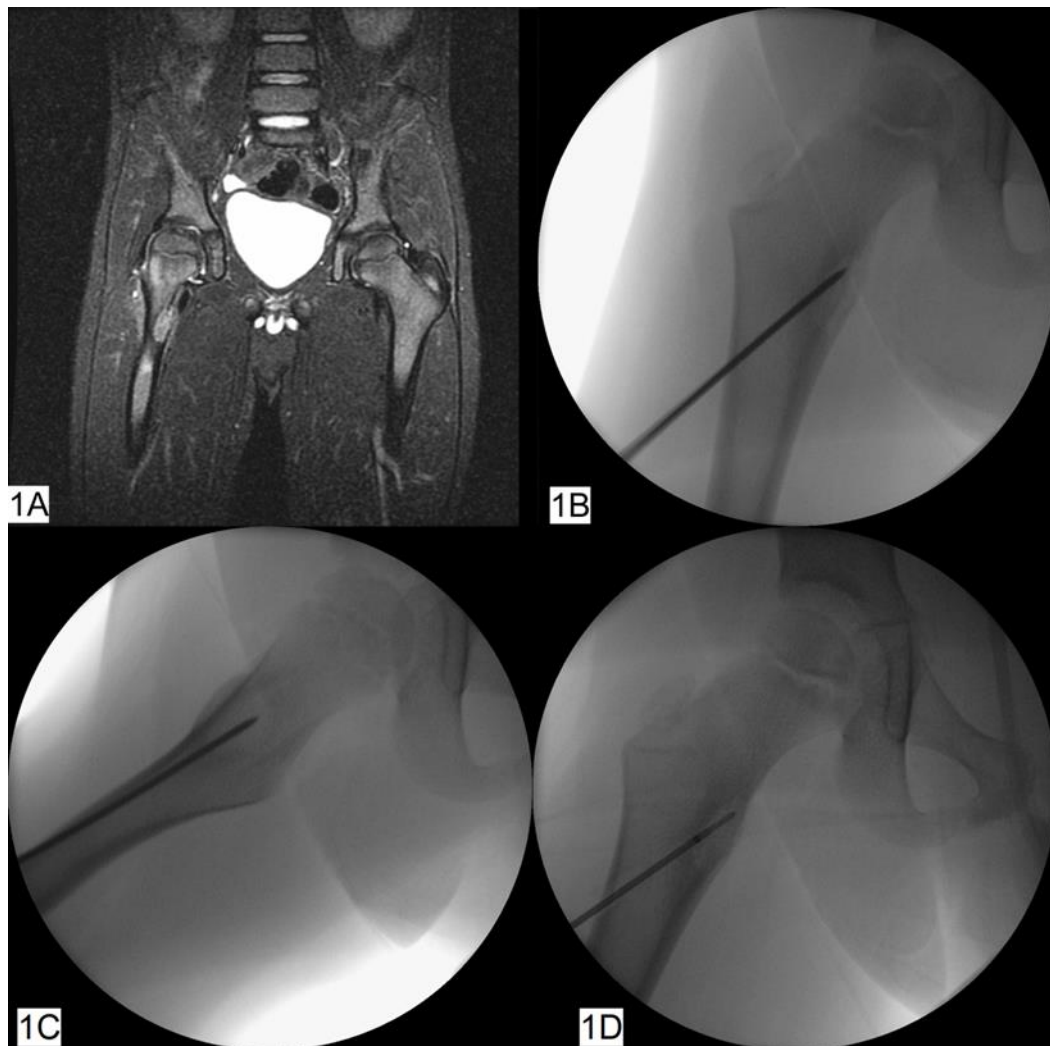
A - Case no.1, MRI aspect of the right sub trochanteric osteoid osteoma. B - K wire placement under fluoroscopic control, anteroposterior view. C - K wire placement under fluoroscopic control, lateral view. D - The fluoroscopic image of RFA probe in the nidus.
